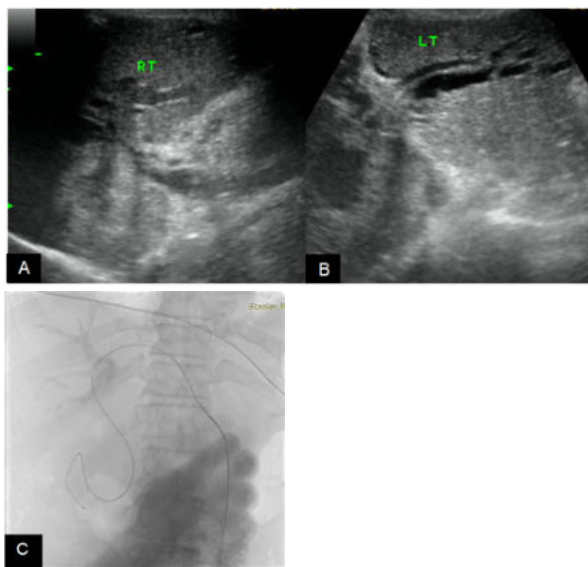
A, B. Ultrasound images showing dilated biliary radicles (Left > Right) in a patient with Carcinoma Gall Bladder Infiltrating CHD. C. Fluoroscopic images showing Left Sided Internal and Externalisation of Biliary catheter done.
